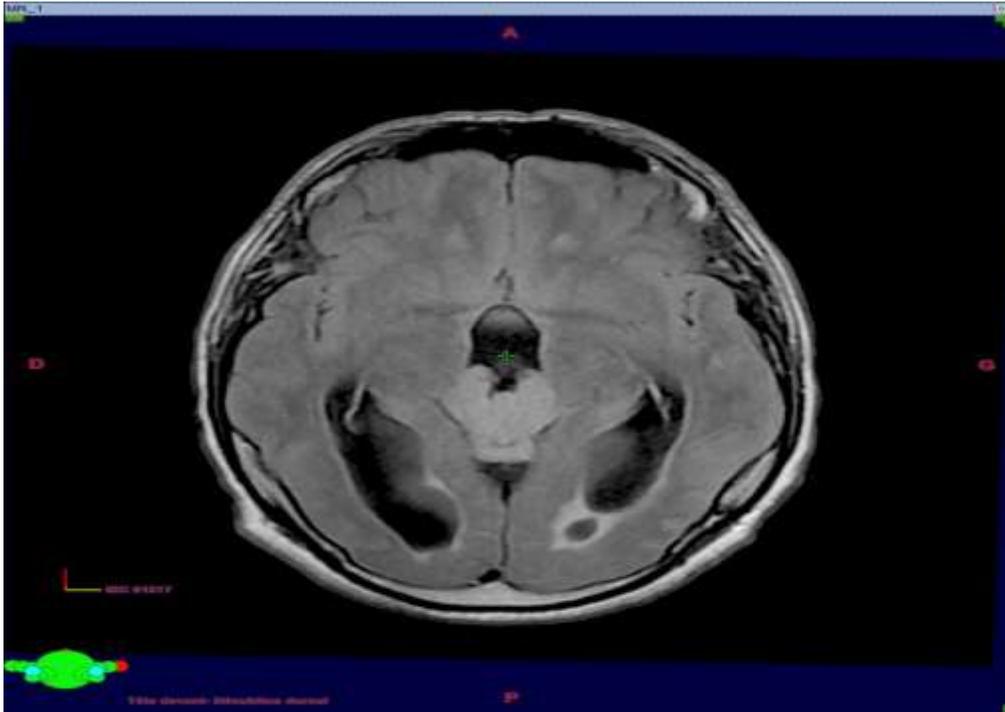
pre-therapeutic MRI image of our patient.
